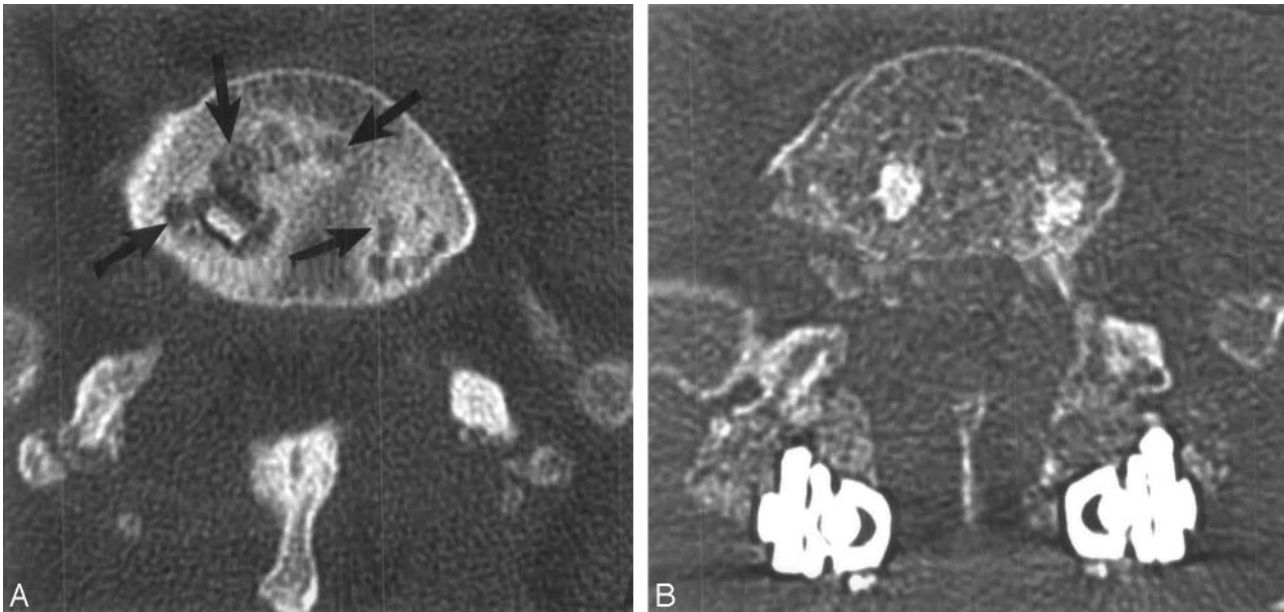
Cystic changes within the endplates adjacent to the implants. *A*, Five months after surgery in a 62-year-old woman, CT scan shows cystic changes (arrows) in the endplates at the L5-S1 level on an axial image. *B*, Twenty-one months after the application of posterior instrumentation, CT scan shows that the cystic changes are much less prominent as the fusion is progressing to solid bony union.
